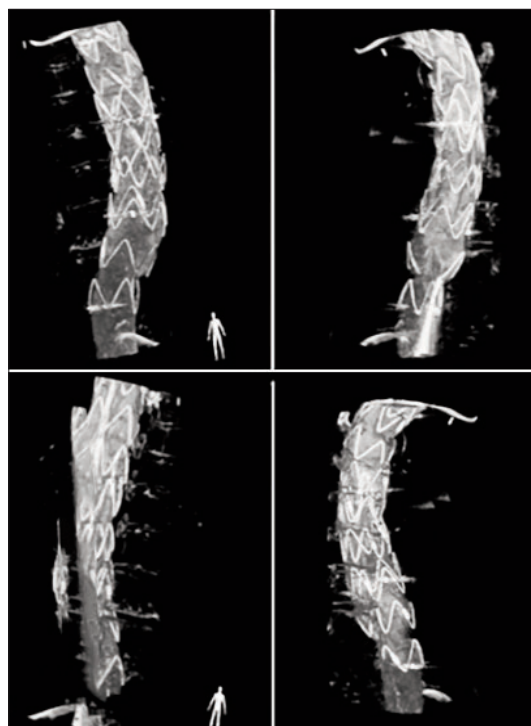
CT images showing multiple incidences of post-procedural stent-graft implant: (A) - anterior; (B) - left side; (C) - posterior; (D) - right side.
